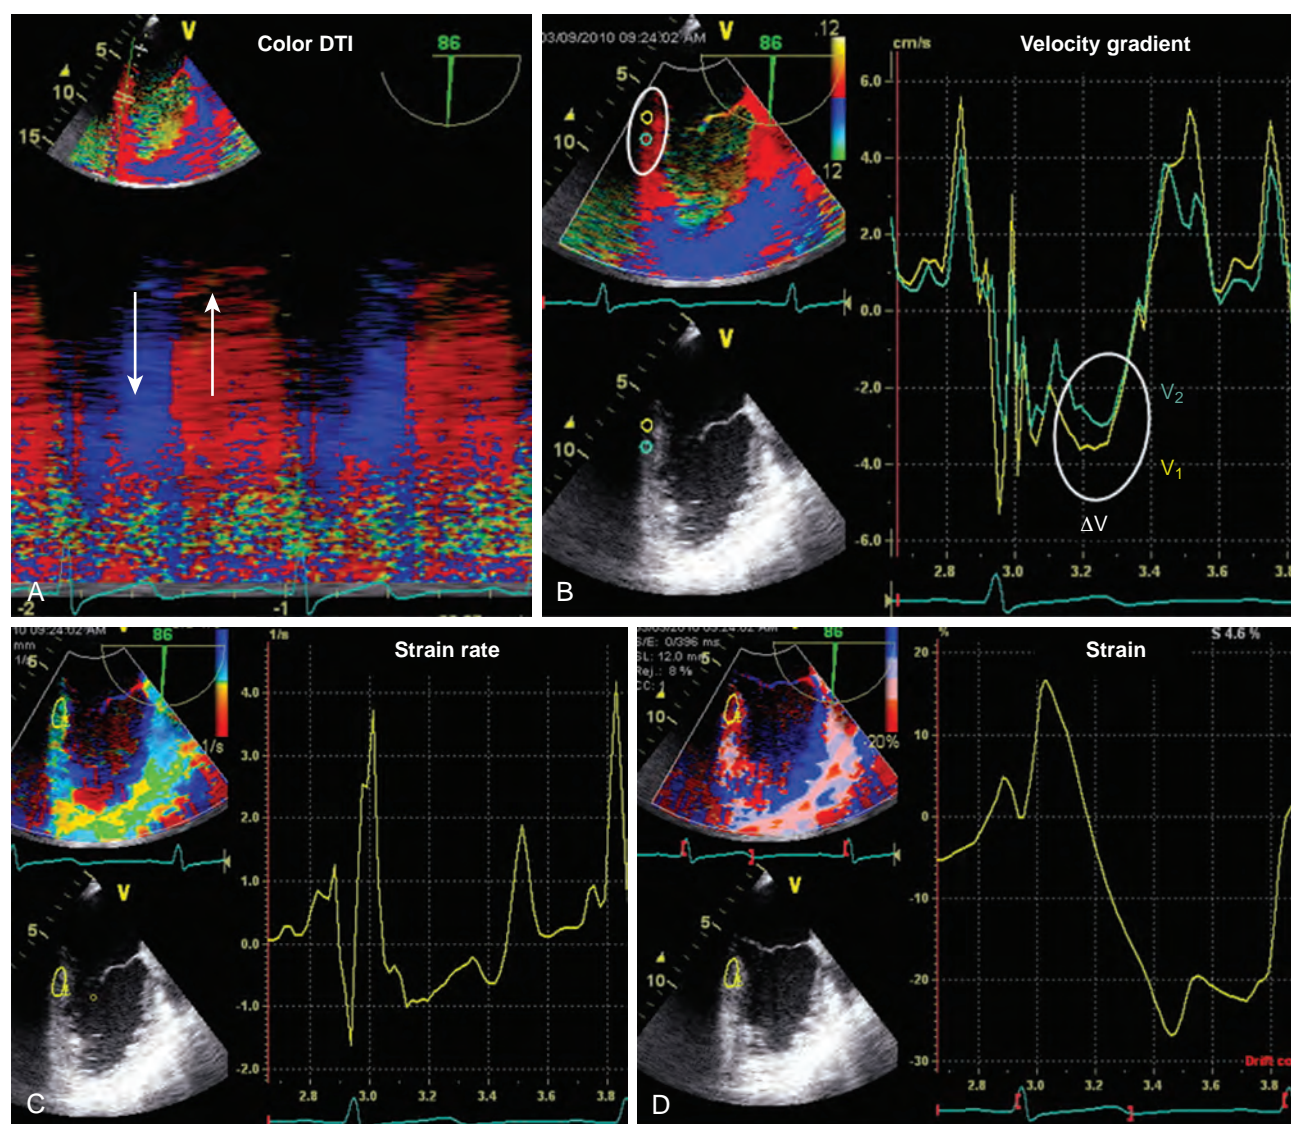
Doppler strain and strain rate. (A) Activation of Doppler tissue imaging (DTI) function allows imaging of myocardial velocities in color, here with M-mode (from the inferior wall in a mid-esophageal two-chamber view). The velocities are directed away from the transducer in systole (and colored blue) and toward the transducer in diastole (and colored red). (B) Spectral display of myocardial velocities from within sample volumes (insert panel at left) demonstrates a velocity gradient (ΔV). Basal velocity (V_1) is greater than apical velocity (V_2) as the inferior wall shortens along its long axis. (C) The velocity gradient (ΔV) of these points is used to calculate strain rate (SR). (D) Integration of SR over time (Δt) derives strain.
